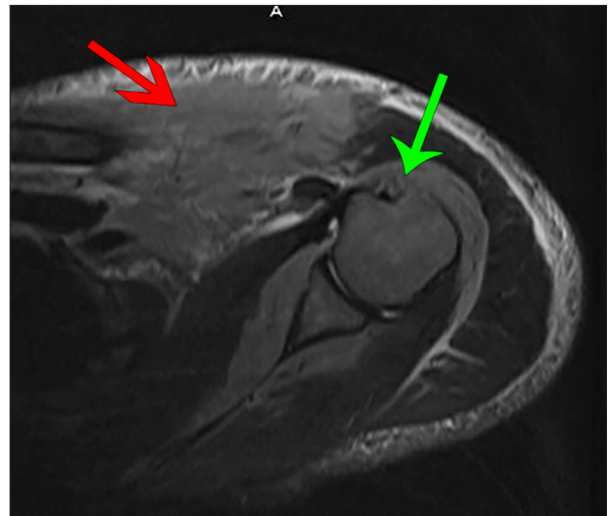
Magnetic resonance imaging of the left shoulder: soft tissue component of the mass (red arrow) and infiltration of the mass into the bone marrow (green arrow).
